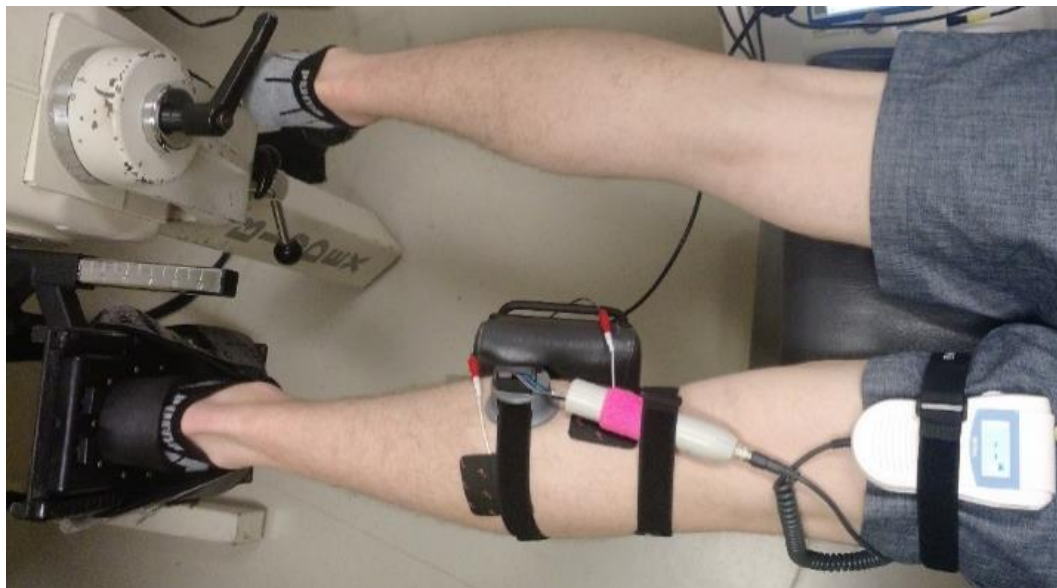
A subject is fitted with a modified portable continuous wave (CW) ultrasound probe and stimulation electrodes on a modified commercial Biodex II dynamometer.
